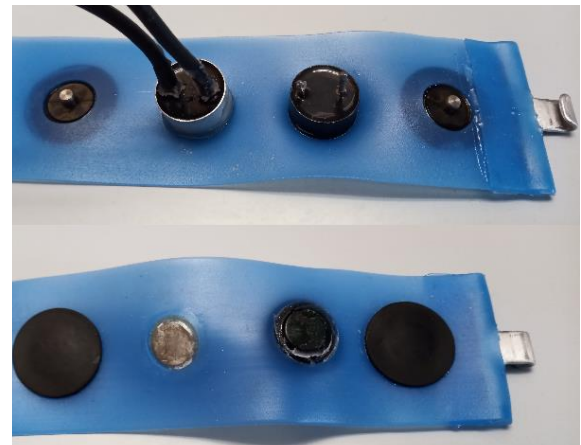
Belt prototype for combined EIT and UST. EIT electrodes outside, ultrasonic transmitter and receiver inside
